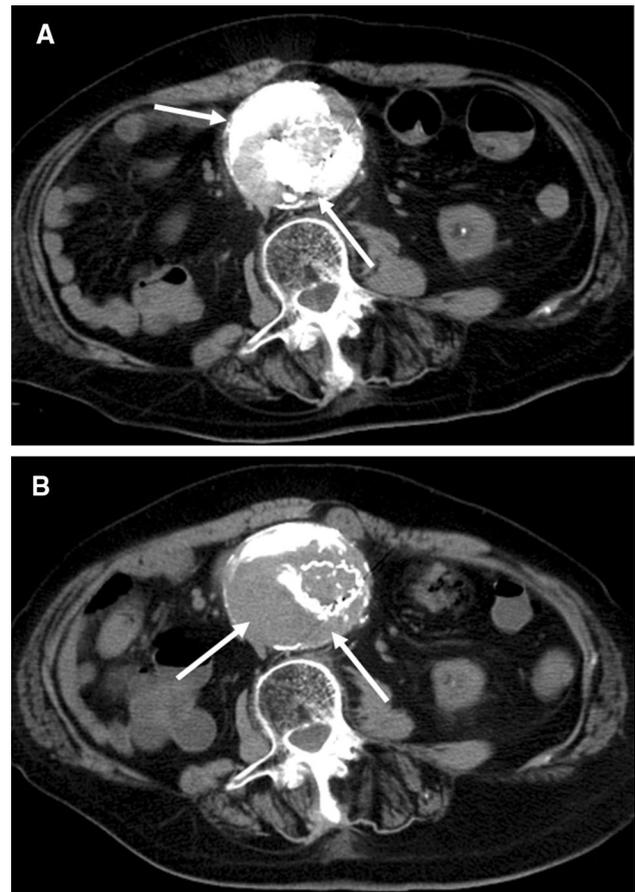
An 80-year-old female 48 months after EVAR with an Endurant[®] AAA stent-graft system. A CT 1 week after translumbar percutaneous direct sac embolization, CT revealed Lipiodol accumulation in the sac (white arrows). B CT 1 year after translumbar percutaneous direct sac embolization, CT revealed sac expansion and wash out of Lipiodol from the sac (white arrows)
